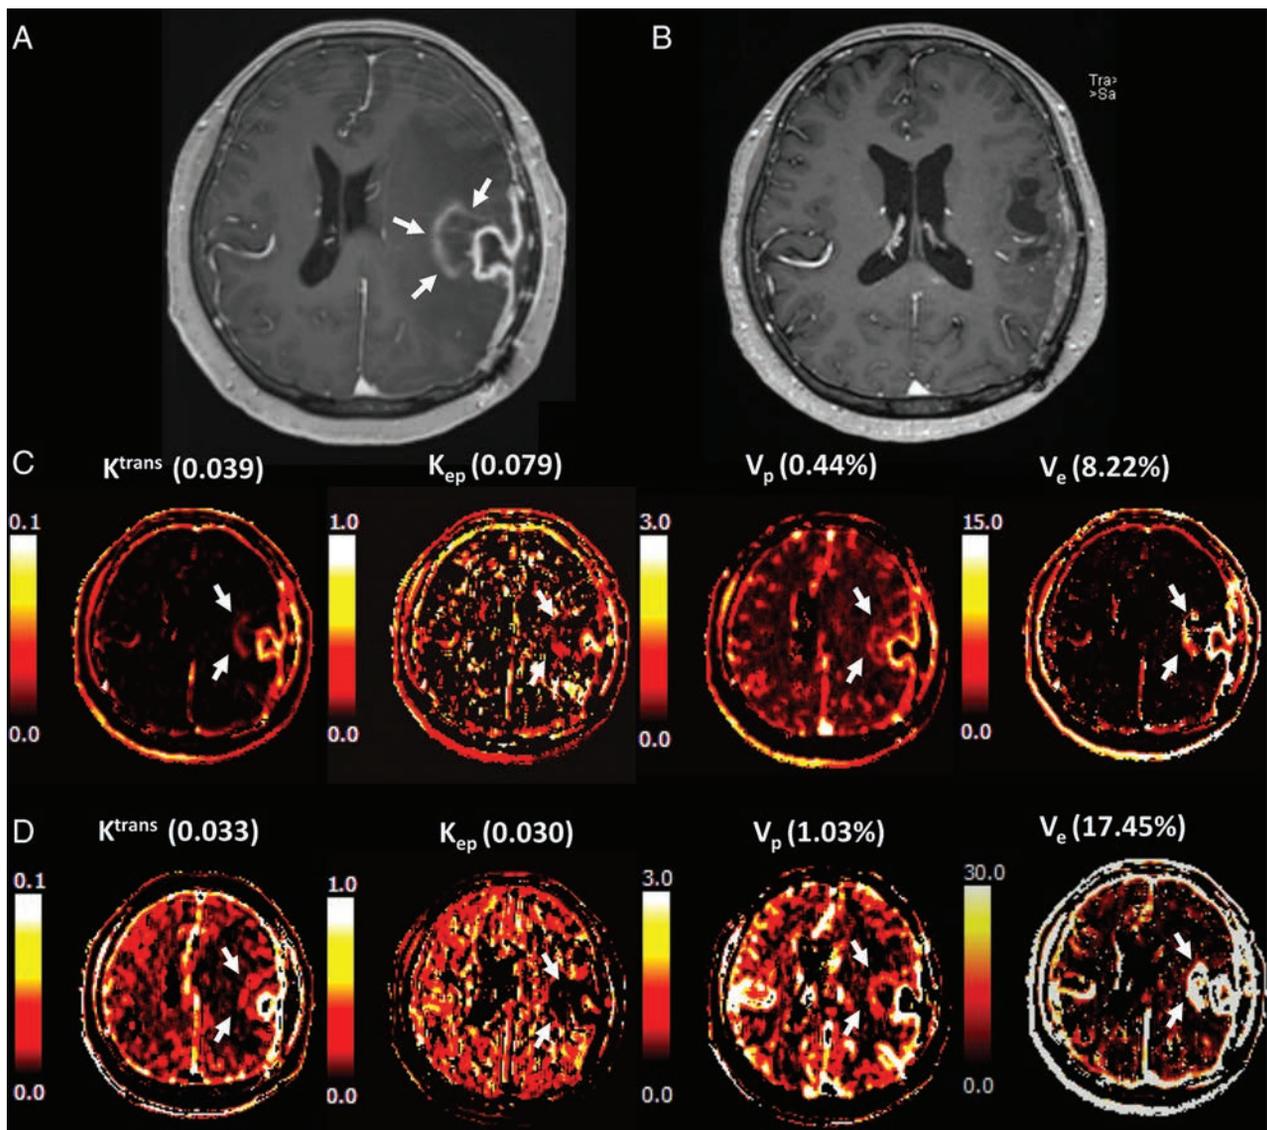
A 57-year-old female patient with surgically proved glioblastoma presented *A*, a newly appeared enhancing nodule on DCE-MR imaging taken 1 month after temozolomide chemoradiation. *B*, The lesion had disappeared after 6 cycles of temozolomide chemotherapy, defining the lesion as a pseudoprogression according to the Response Assessment in Neuro-Oncology criteria. The pharmacokinetic DCE maps, especially those for K^{trans} and K_{ep} , showed less intense signals from both *C*, the fixed T1 and *D*, measured T1 methods.
